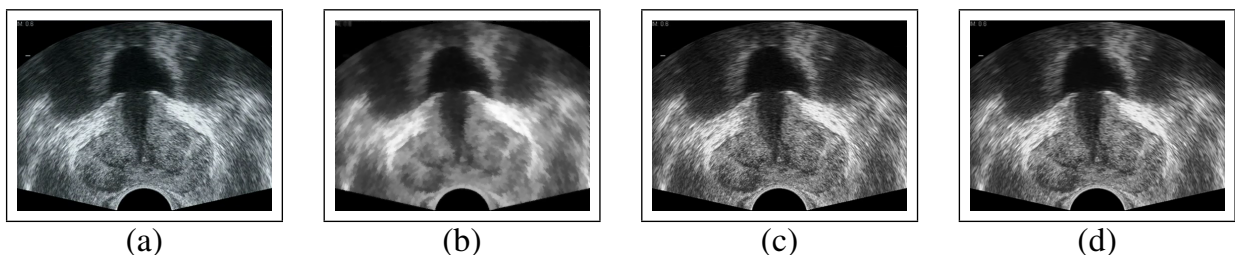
Comparison of denoising methods applied to real prostate ultrasound images. Note that the better algorithms (SRAD, OBNLM) preserve detail much more effectively. These images all have the best SSIM score for the specific denoising method. (a) Original (b) SBF MSE: 280, SSIM: 0.65(c) SRAD MSE: 5.68, SSIM: 0.99 (d) OBNLM MSE: 12.9, SSIM: 0.98.
